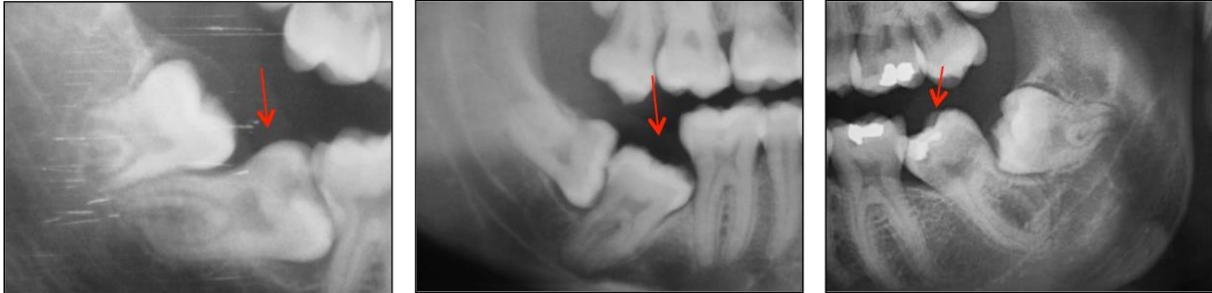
Panoramic radiographies evidencing lack of space and a mechanical obstacle to normal eruption process. Red arrows: Second lower molars impaction.
